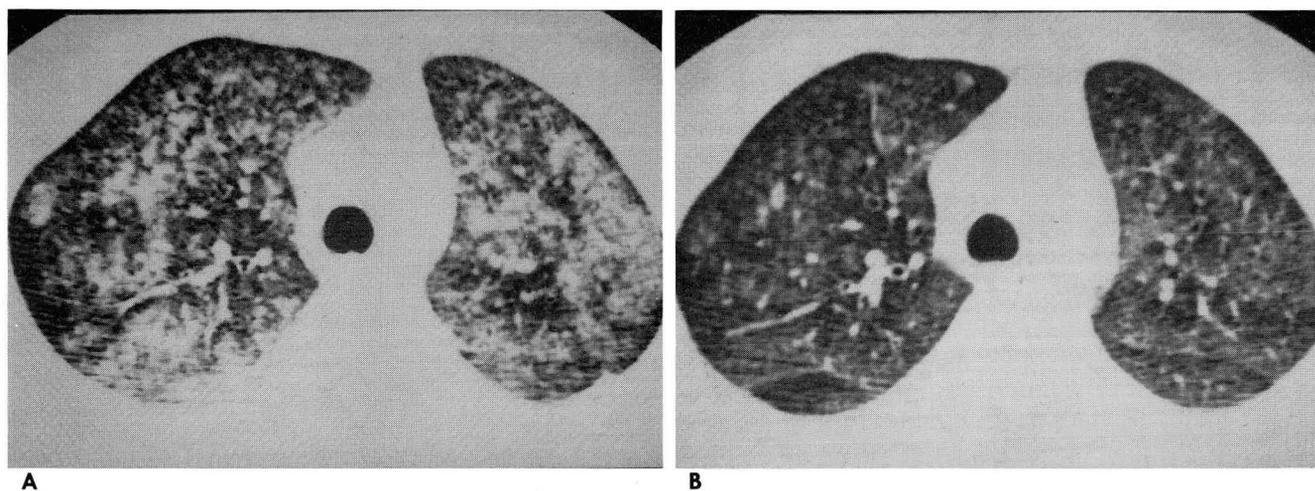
Thin-section CT findings of 25-year-old man with fat embolism.
